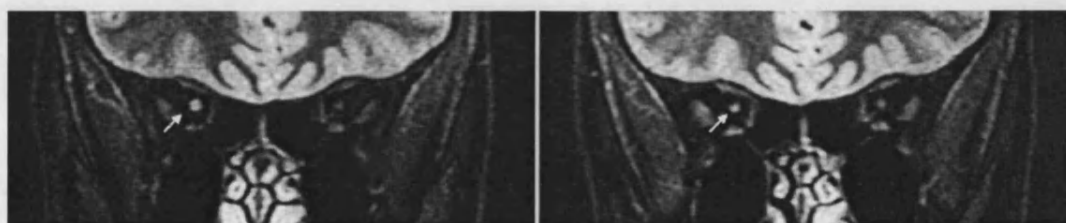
STIR MRI demonstrating optic nerve swelling at baseline (left) and optic nerve atrophy after six months (diseased nerve arrowed) in a 27 year old man with right optic neuritis.
